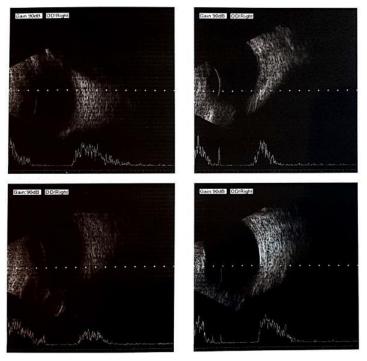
Right eye ultrasound.
